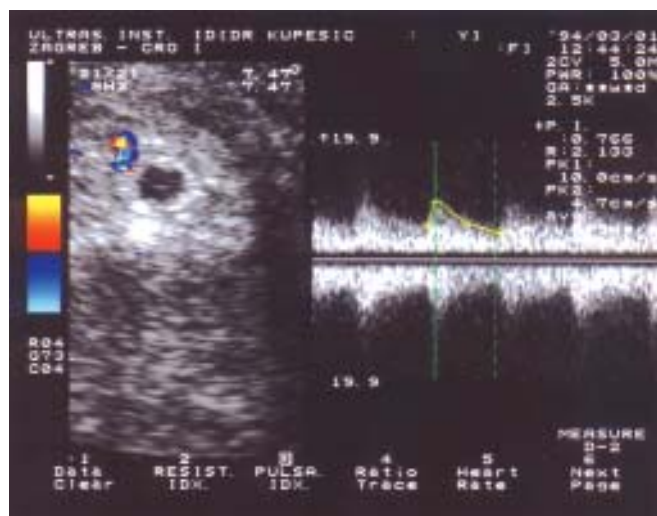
Transvaginal color Doppler image of an early gestational sac. Blood flow signals derived from spiral arteries demonstrate low vascular resistance ($PI = 0.77$)
